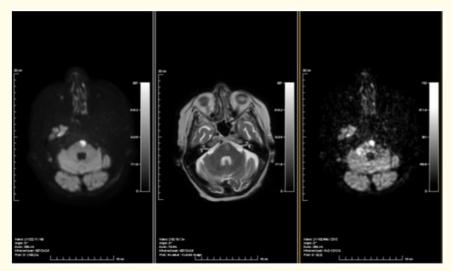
Left pontine acute ischemic infraction with on the left image FLAIR hyperintensity, on the middle image T2 hyperintensity and on the right image diffusion weighted restriction.
